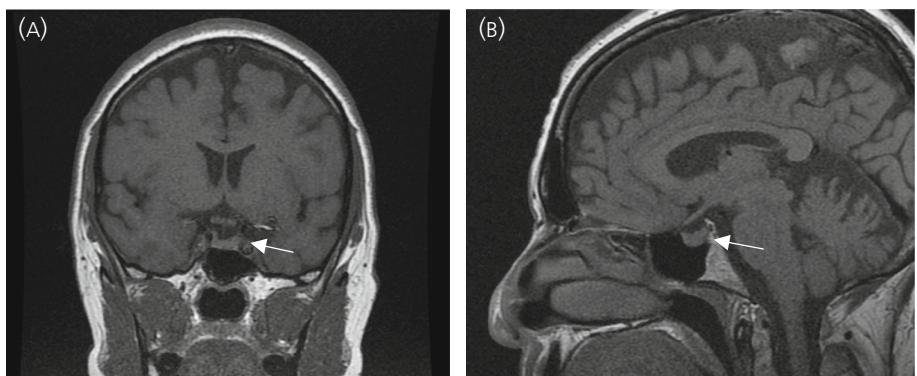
Magnetic resonance imaging of a young patient with idiopathic diabetes insipidus showing the absence of the bright spot of the posterior pituitary gland (white arrow). (A) Non-contrast T1 coronal sequence. (B) Non-contrast T1 sagittal sequence
